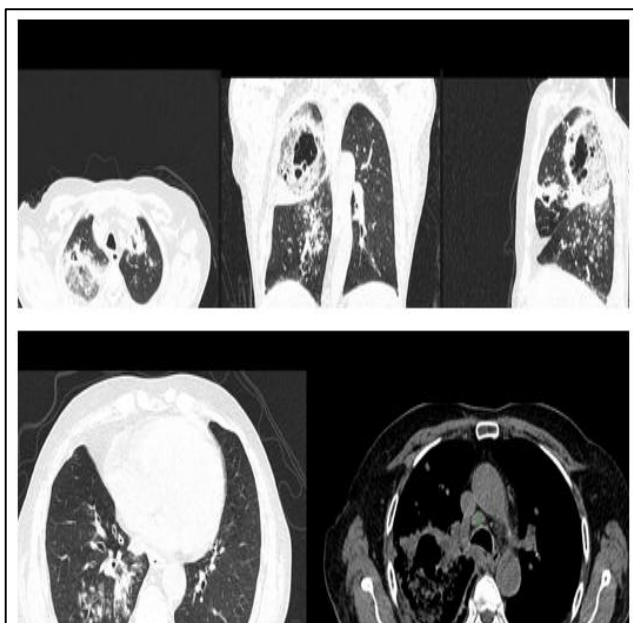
HRCT chest images- fibrocavitary upper-lobe disease with centrilobular nodules/tree-in-bud endobronchial spread.
